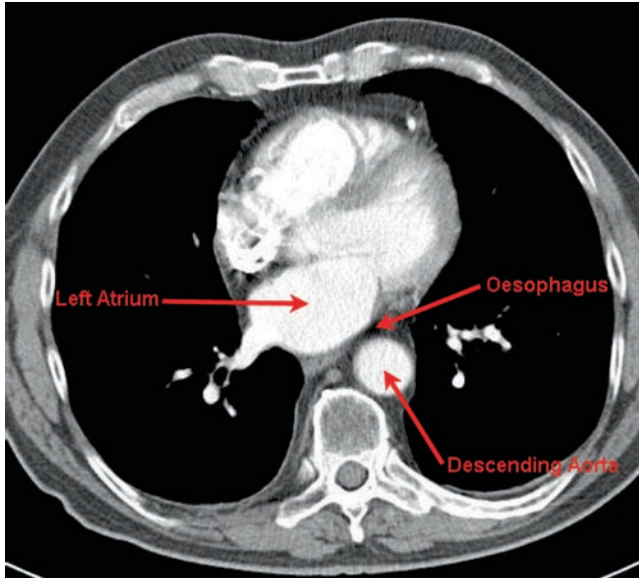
Thoracic CT slice taken at the level of T10 showing the relationship of the esophagus to the left atrium and descending aorta.
